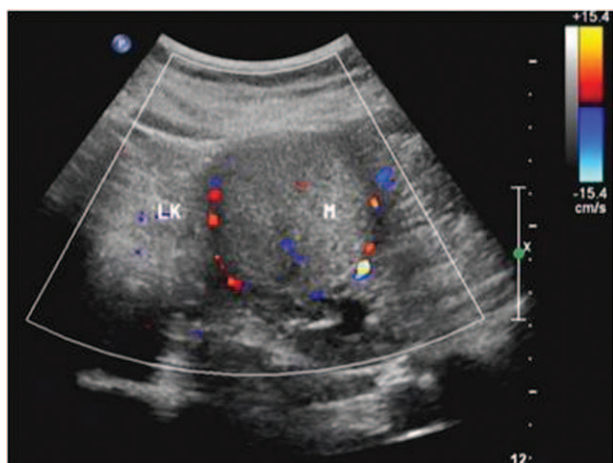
Ultrasonography of the abdomen shows increased blood flow signal around the hypoechoic mass. LK=left kidney, M=mass.
